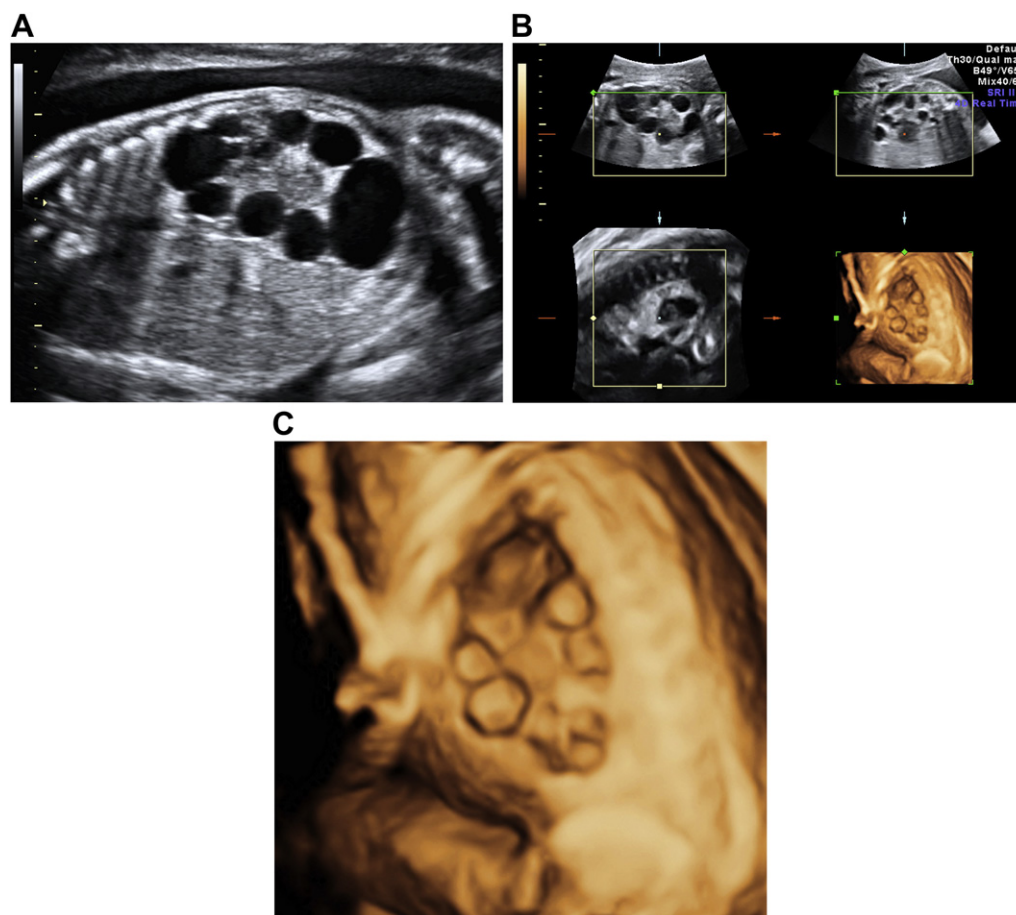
The ultrasound images of multicystic dysplastic kidney (MCDK). (A) Traditional longitudinal view of MCDK by two-dimensional (2D) ultrasound (US). (B) Orthogonal multiplanar views and initial surface-rendered image of MCDK by 3D US. (C) Surface-rendering image of MCDK by 3D US.
